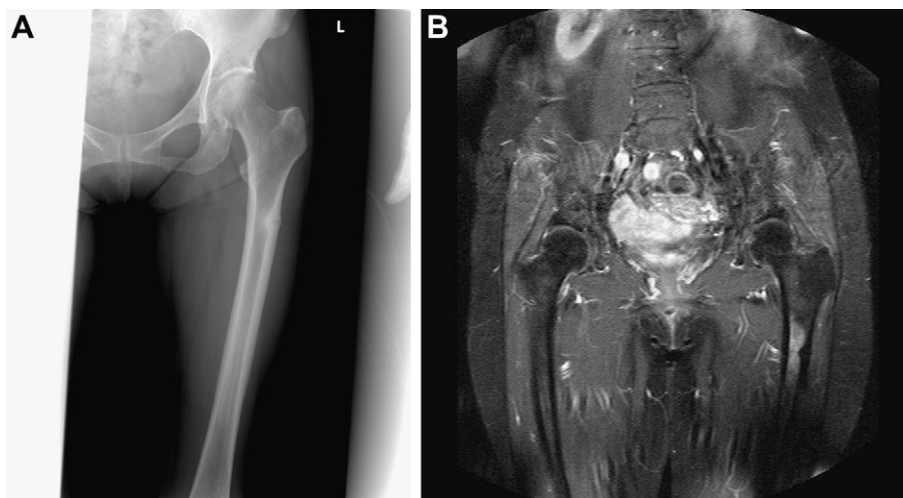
(A) Radiograph of the left proximal femoral shaft showing a radiolucent line and focal thickening of the lateral cortex. (B) Magnetic resonance imaging reveals the same finding, which indicates stress fracture. The subsequent femur insufficiency fracture occurred in the same area.
